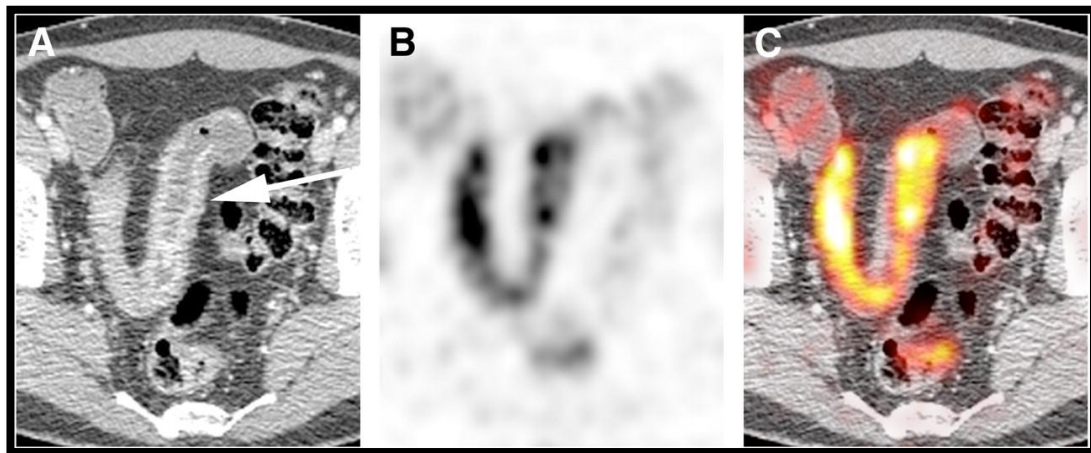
PET/CT SCAN ENTEROGRAPHY
